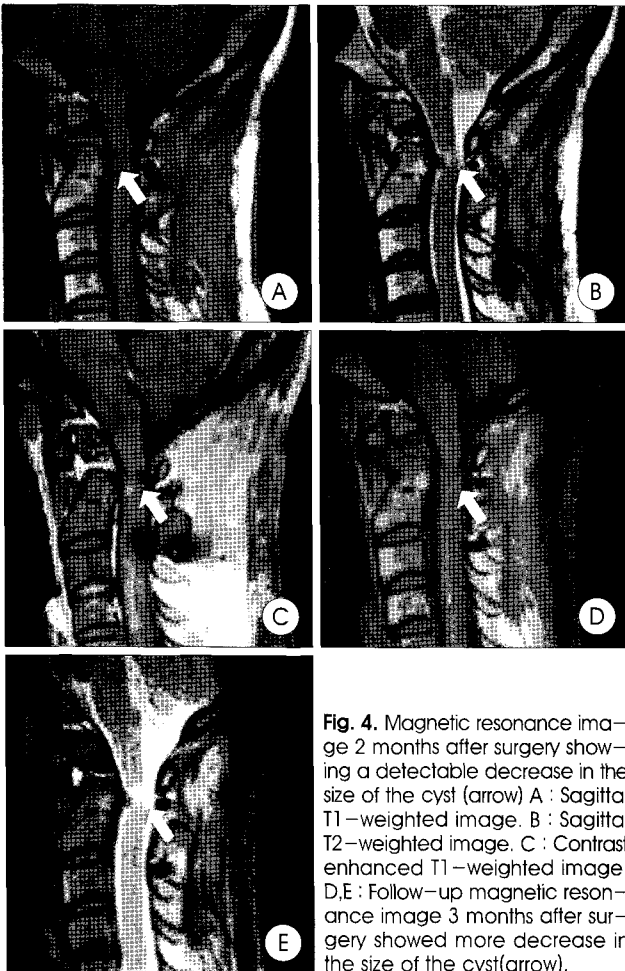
Magnetic resonance image 2 months after surgery showing a detectable decrease in the size of the cyst (arrow) A : Sagittal T1-weighted image. B : Sagittal T2-weighted image. C : Contrast enhanced T1-weighted image. D,E : Follow-up magnetic resonance image 3 months after surgery showed more decrease in the size of the cyst (arrow).
